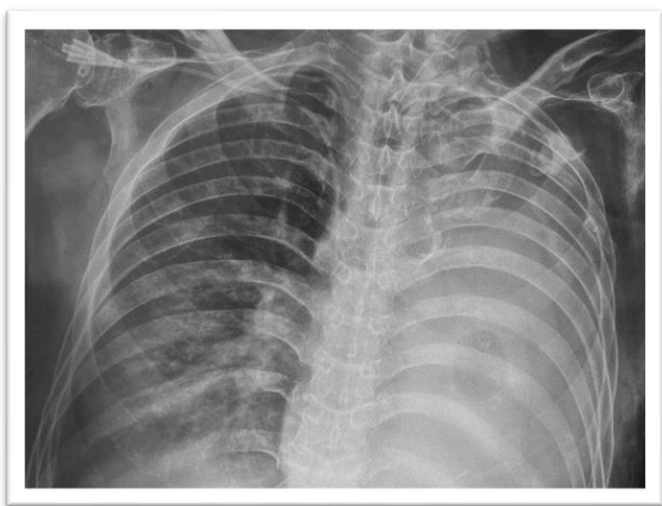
Chest radiograph showing left sided lung opacification.
